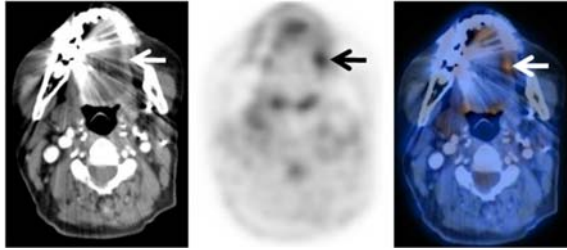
A second primary tumor in the left lateral tongue in a 72-year-old patient with a history of alveolar ridge cancer status post surgery for 3 months. Axial images of PET/CT scan shows focally increased FDG uptake at the left lateral tongue (SUV_{max} 3.9), without any evidence of discrete mass on contrast enhanced CT scan. This finding was initially interpreted as physiological tongue uptake. However, the physical examination showed a palpable mass in this region, biopsy at the left lateral tongue on the next day confirmed a second primary tumor in the left lateral tongue. Tumor size was 0.9 cm
